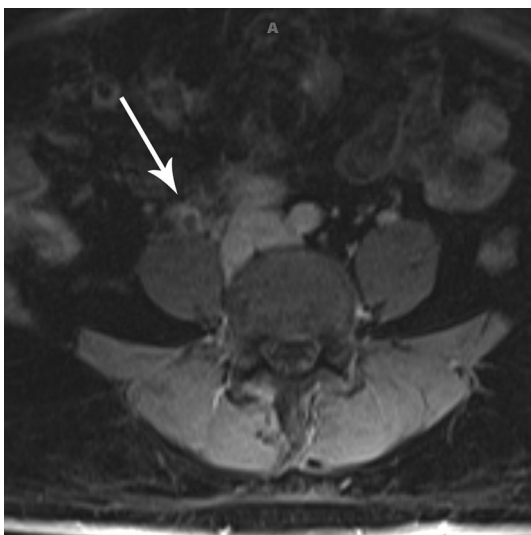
OVT on MRI. T1WI post-contrast fat saturation image shows intraluminal filling defect with the enhancement of the distended ovarian vein wall and surrounding inflammation indicating thrombophlebitis. Images courtesy of Cary L. Siegal, MD, Mallinckrodt Institute of Radiology
